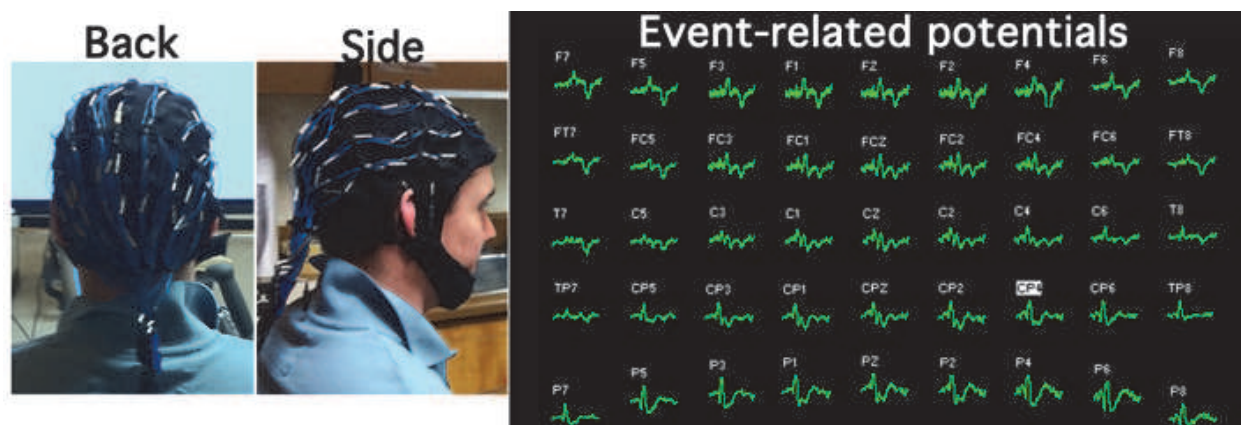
Left: Back and side views of a participant wearing a 64-channel electroencephalography (EEG) cap. Wires from individual electrodes are collected in a bundle at the back of the head. Right: Event-related potentials (ERP) are shown across each of the different electrode sites, listed according to their position on the head. In this example a motor response (button press) is made in response to a decision task. On inspection, the electrode sites in the region surrounding P1 and P3 have large ERP amplitudes. EEG ERP are typically in the micro-volt range. Data shown in this figure were collected outside of the MRI scanner room and are therefore free of MRI-related artifacts.
